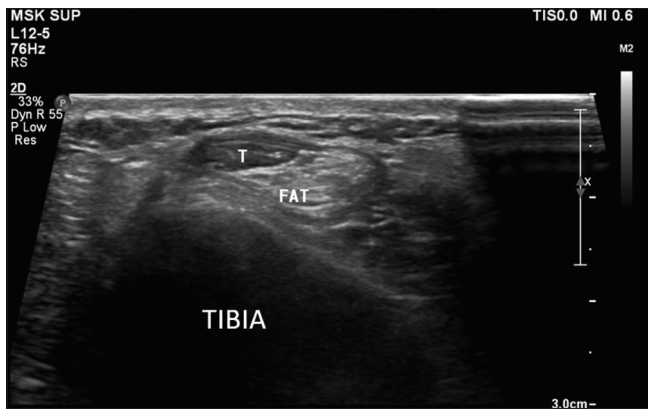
Ultrasound image perpendicular to shin of tibia showing tibialis anterior tendon sheath with hypoechoic tendon and echogenic fat inside the tendon sheath
